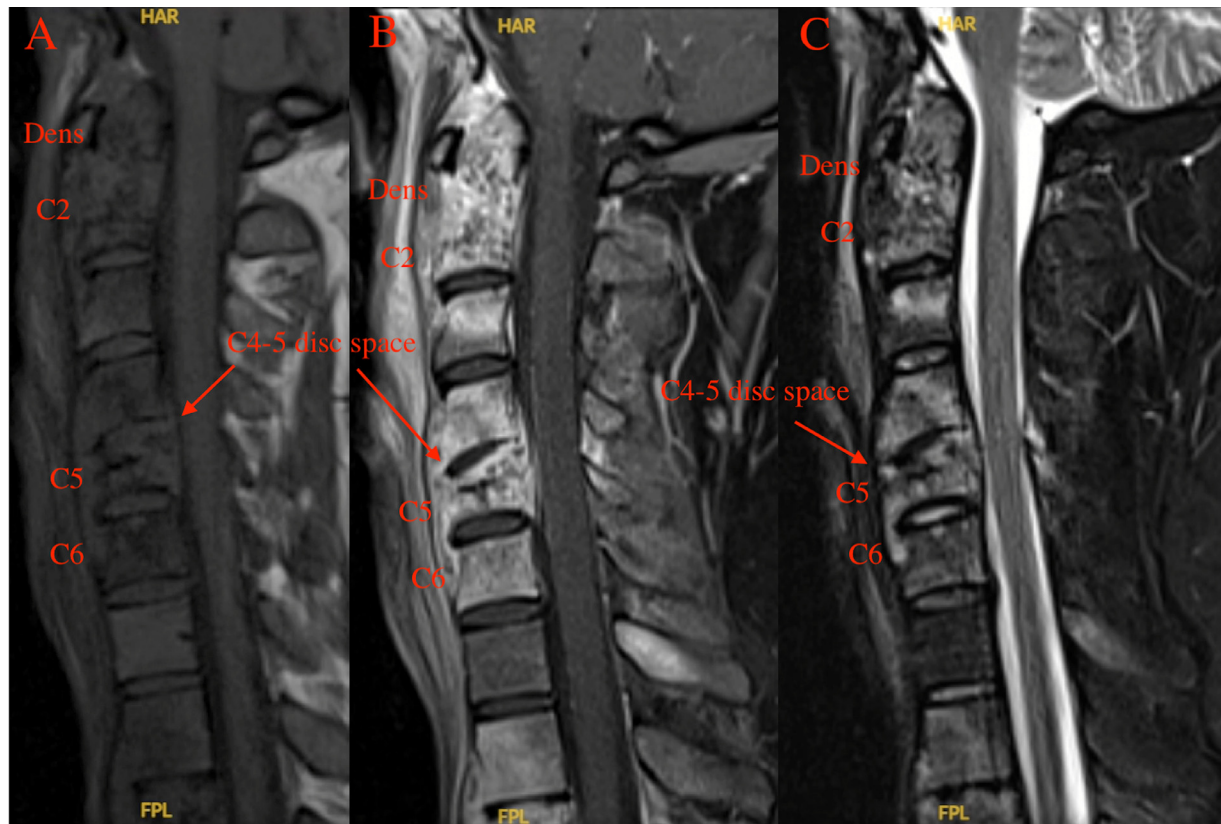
T1-weighted pre-contrast (A), T1-weighted post-contrast (B), and STIR MR images in the sagittal view. Enhancing destructive signal abnormalities are demonstrated throughout the cervical spine, including the odontoid process and the C2, C5, and C6 vertebral bodies (red arrows, vertebral levels labeled). The C5 vertebral body demonstrates a moderate anterior compression deformity with associated moderate canal stenosis (C5 body labeled in red). There is a loss of height at the C4-5 space (disc space labeled in red, denoted by arrow). The cervical spinal cord does not demonstrate abnormal caliber, signal intensity, or enhancement.
